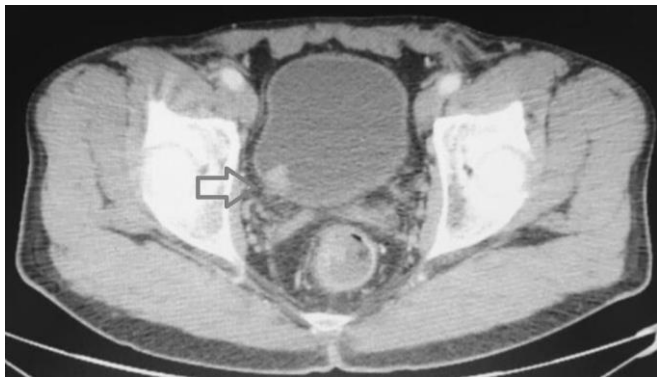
Computed tomography scan showing heterogeneously enhancing bladder mass (arrow)
